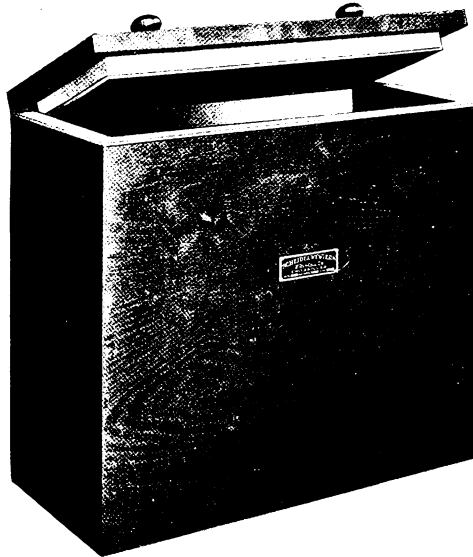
Lead-lined, X-ray-proof box.
